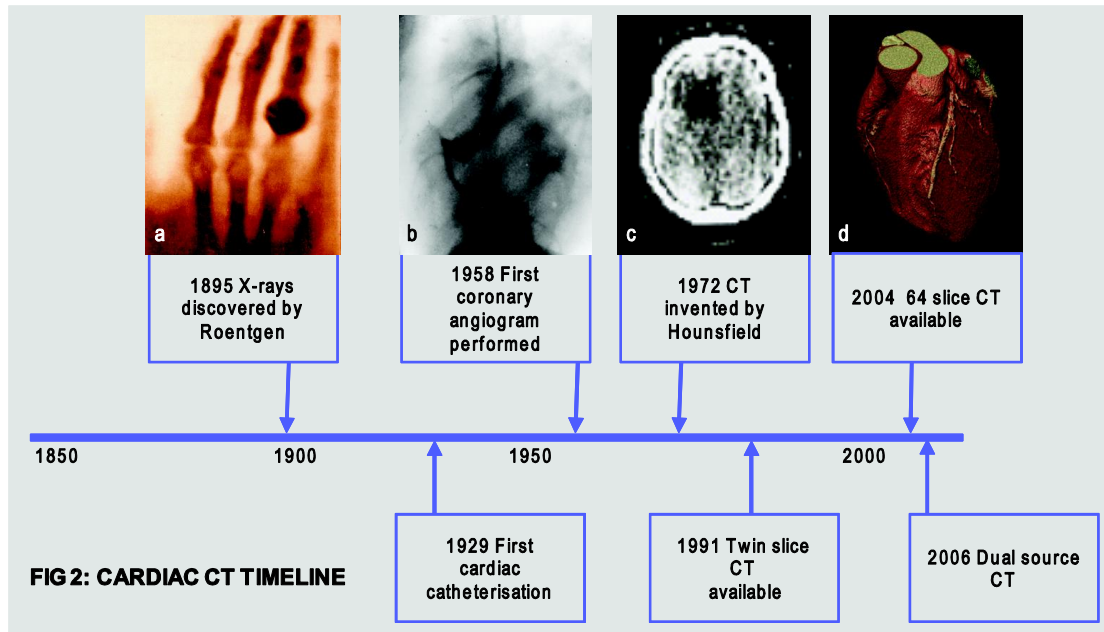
Timeline of the development of cardiac CT
